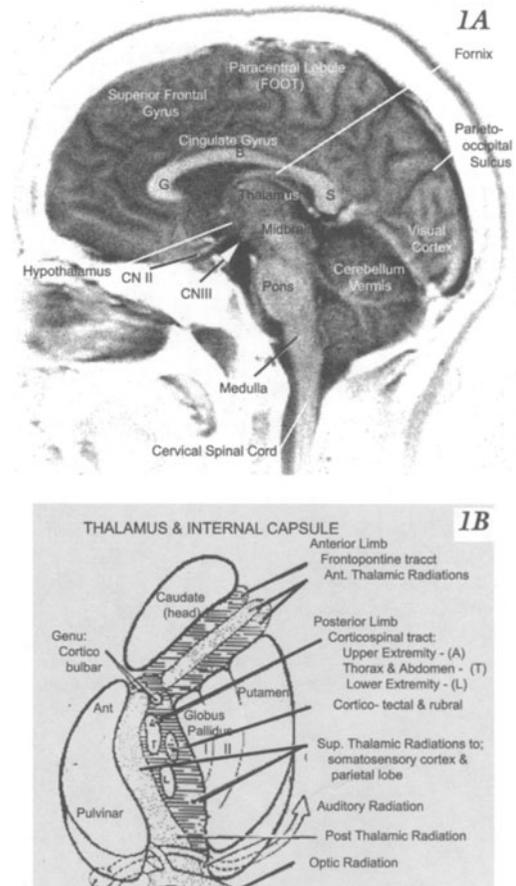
Brain in Sagittal plain demonstrating. The relationship between brain stem, diencephalon and cerebrum. (MRI weighted T1.) Location of thalamus. A. MRI B. Gross Brain..
